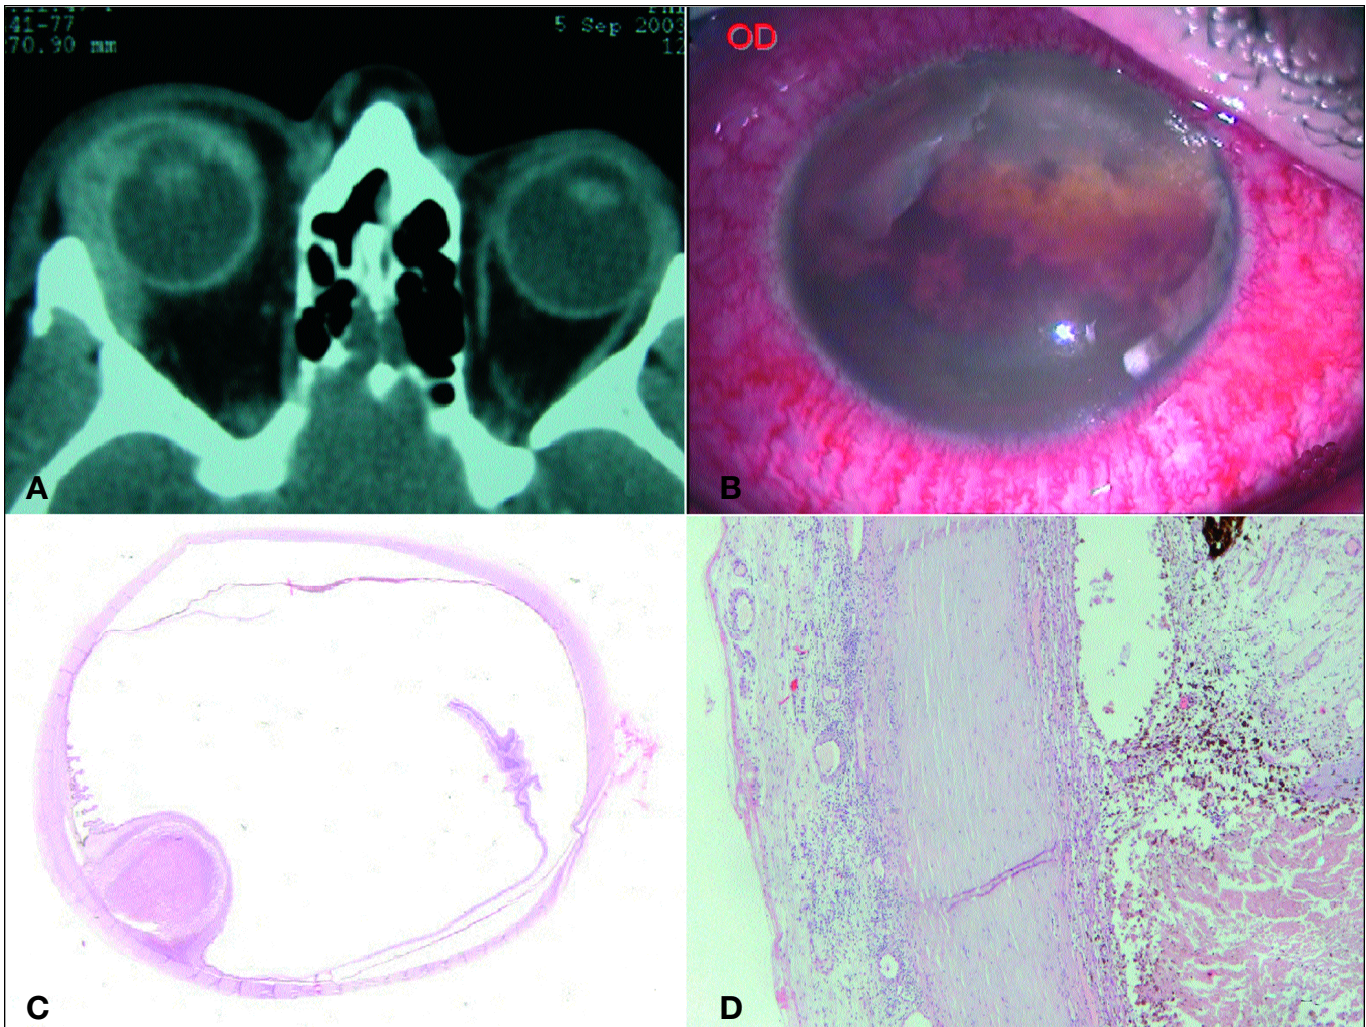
(A) Computed tomographic scan of the orbits, with contrast enhancement, axial view. (B) Severe conjunctival vascular congestion and ciliary flush, anterior chamber filled by neoplastic tissue. (C) Macroscopic section of the enucleated eye, tumor involving the ciliary body (H-E, original magnification x 20). (D) Chronic inflammatory infiltrate overlying the sclera (episcleritis) (H-E, original magnification x 40).
